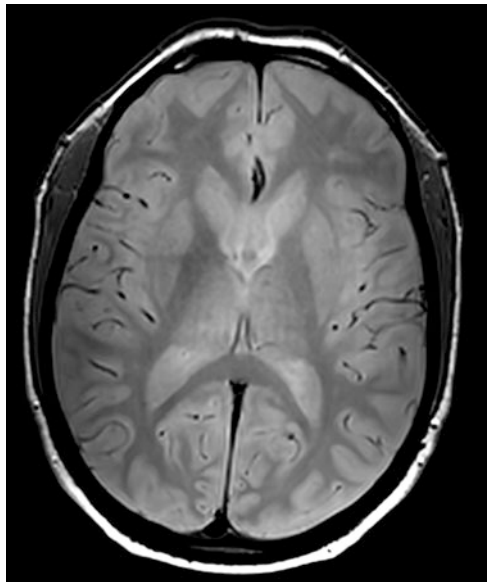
Axial proton density-weighted MR image of the human brain
